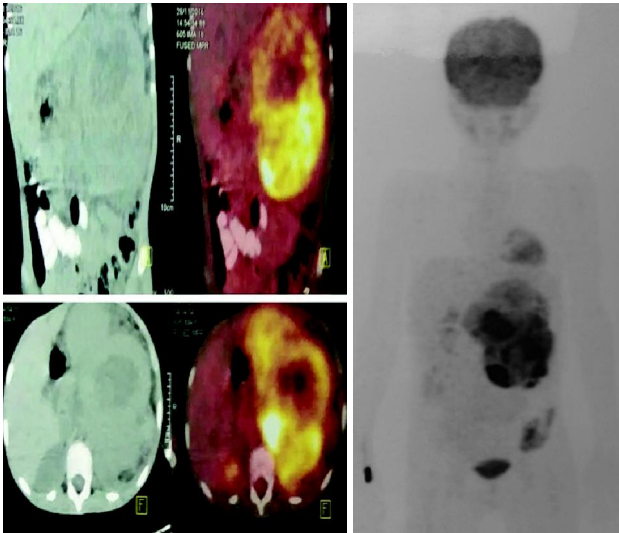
(a): Appearance of the left suprarenal mass in PET-CT scan showing increased metabolic activity; (b) Whole body bone scan shows metastatic involvement of left ilium
